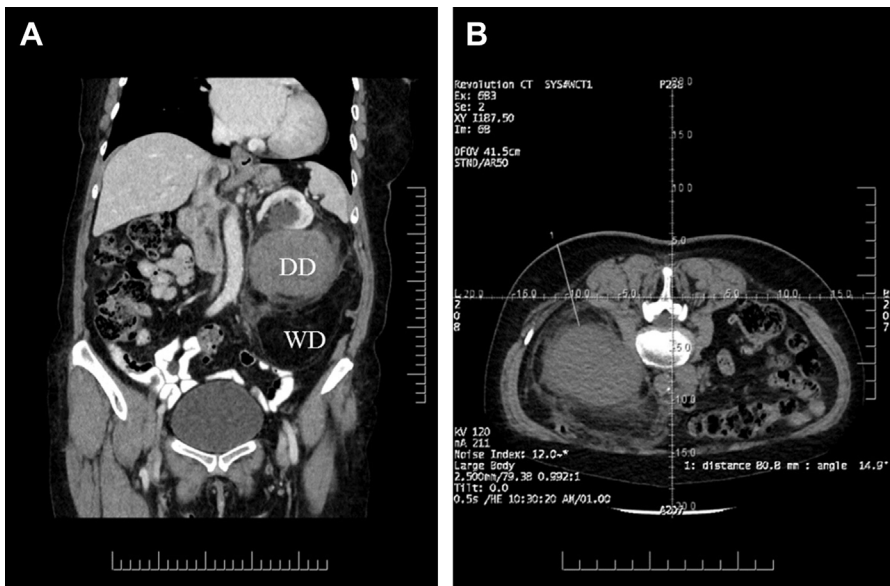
Establishing the diagnosis of a retroperitoneal sarcoma. Diagnostic CT scan of the abdomen and pelvis demonstrates a retroperitoneal mass with areas suspicious for dedifferentiated (DD) and well-differentiated (WD) liposarcoma (A). A diagnostic biopsy was performed using CT-guidance of the high-grade DD area, which confirmed the diagnosis of liposarcoma (B).
